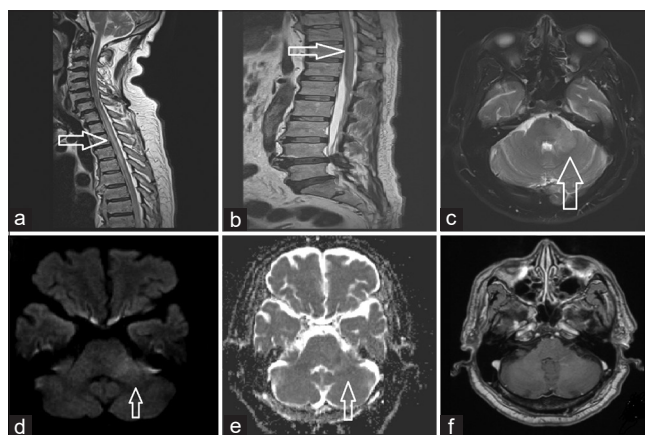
Magnetic resonance imaging showing longitudinally extensive myelitis from C6 to conus (a, b). Brain imaging revealing T2 hyperintensity involving pons and left middle cerebellar peduncle (c) with patchy restricted diffusion (d, e) and faint peripheral contrast enhancement (f)
